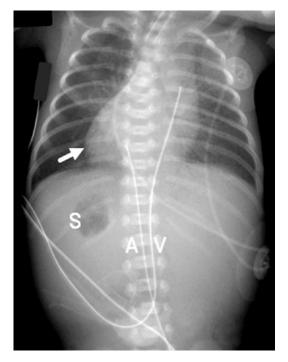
On the first day of life, this newborn who was known to have situs inversus had an umbilical venous catheter (UVC) (V) and umbilical arterial catheter (UAC) (A) placed prior to a chest and abdomen radiograph. The cardiac apex (*arrow*) and gastric air bubble (S) are on the right and the liver shadow is on the left. The tip of the UVC is more cephalad than expected, within the lumen of the left-sided hemiazygous vein in this patient found to have situs inversus and an interrupted IVC and hemiazygous continuation to the hemiazygous arch which drained to the SVC. In this situation, situs inversus, the L SVC drains to the morphologic right atrium and a persistent R SVC (if present) would drain to the coronary sinus. This patient does not have a persistent R SVC
